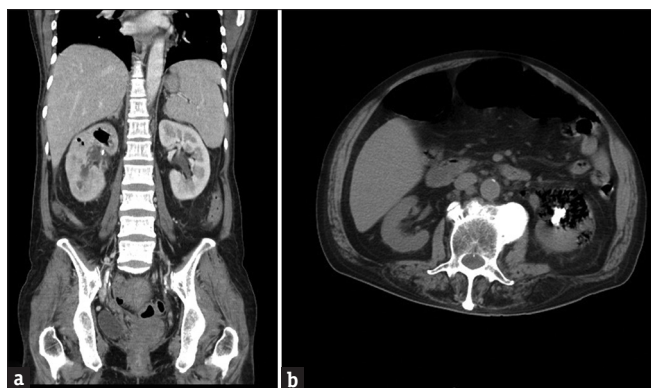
(a) Computed tomography scans of a 55-year-old female with right side class 2 emphysematous pyelonephritis; (b) Computed tomography scan of a 68-year-old male with left side class 2 emphysematous pyelonephritis and renal stones
